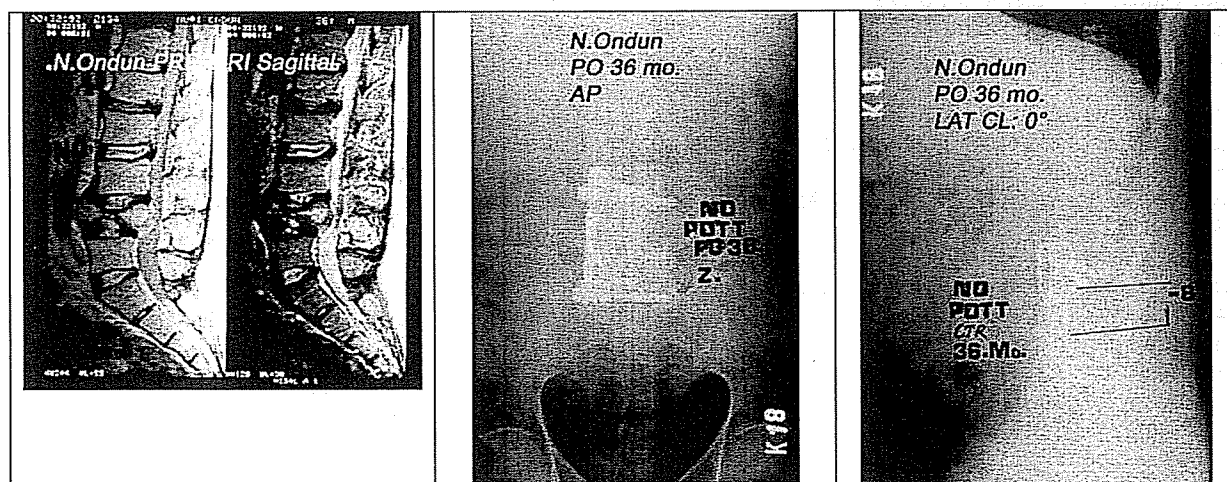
Preoperative magnetic resonance imaging sagittal view (a) and postoperative 36th month control posteroanterior (b) and lateral (c) radiograms of 36 years old male (N.O.) with Pott's disease in the lumbar 4 vertebra. Two mobile segments were instrumented with anterior Z - plate and 100 % correction rate was obtained after anterior radical debridement and strut grafting. There was 5° loss of correction and solid fusion mass was observed in the last visit.
